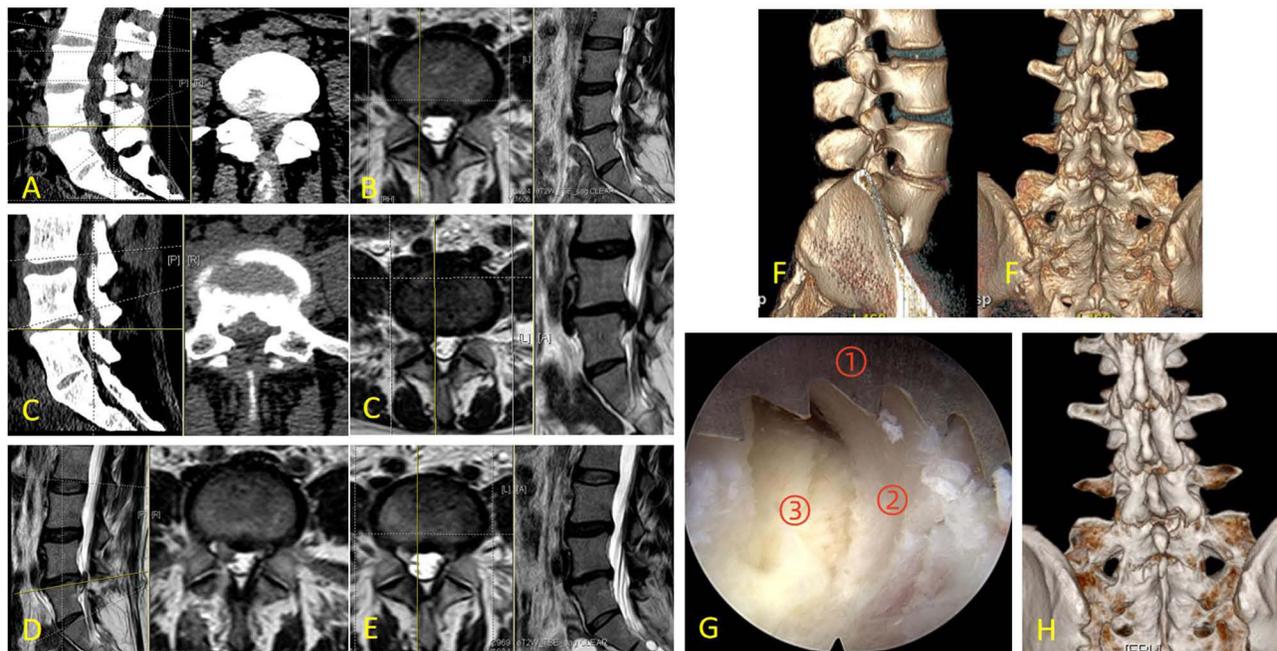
A 37-year-old woman's first visit to the doctor was for "low back pain with numbness and pain in the right lower limb", and the lumbar CT showed a disc herniation in the L4/5 (A), which was treated with PETD, and the follow-up MR showed that the herniated disc had been removed (B). The patient had a recurrence after 3 years, complaining of low back pain with bilateral lower limbs pain, and the lumbar CT and MR showed a disc herniation at L4/5 with lateral socket stenosis (C). PEID was used for revision, and (G) shows that part of the intraoperative lamina was resected with a visualized circular saw ((1 the serration of circular saw, 2 the vertebral plate, 3 the ligamentum flavum). (D and E) are postoperative MR on the first day and at 6 months, respectively, showing that the surgery was successful in removing the herniated disc. And (F-H) show the vertebral plates before and after revision.
